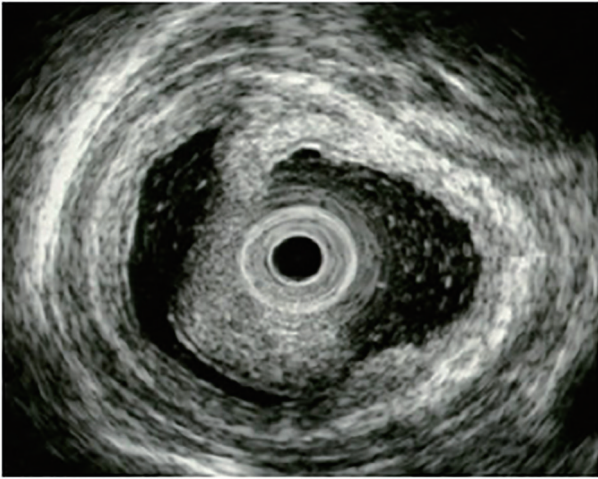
Endoscopic ultrasonography
